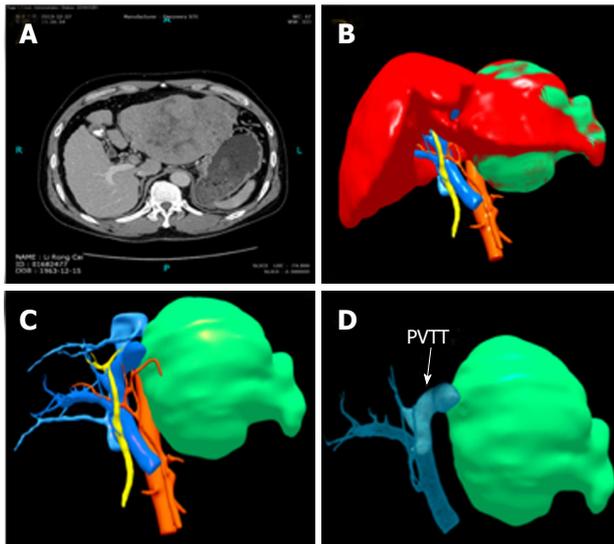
Case 3. A: The computed tomography scan showed the left hepatocellular carcinoma (HCC) and tumor thrombus in the left portal vein (LPV) and portal vein (PV). B and C: 3D reconstruction of the left HCC. D: 3D reconstruction of tumor thrombus in the LPV and PV. PVTT: Portal vein tumor thrombus.
